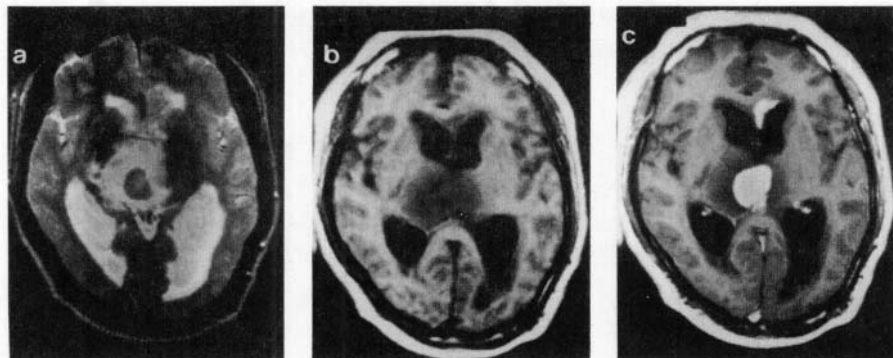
Lymphoma. T2-weighted axial image (a) showing a large lesion with central hypointense area in the right thalamic region with perifocal edema. Another small similar-appearing lesion noted in genu of corpus callosum, anteromedial to left frontal horn of lateral ventricle. These lesions are hypointense on T1 image (b) and show intense enhancement following contrast (c).
